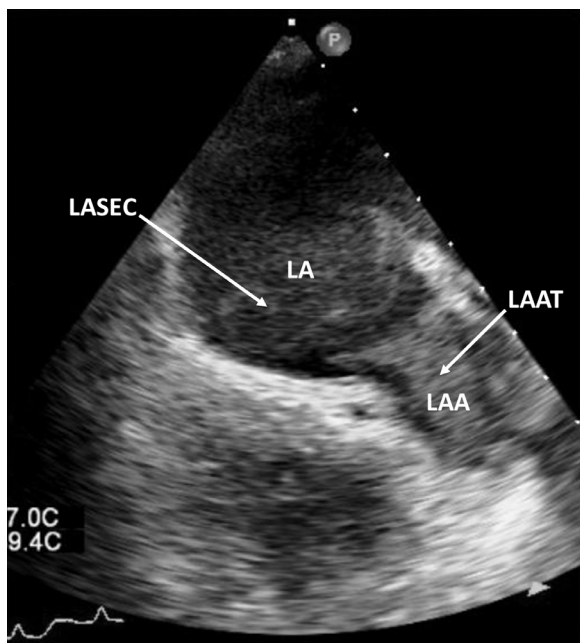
A transesophageal echocardiographic image of the left atrium and left atrial appendage showing left atrial spontaneous echo contrast grade 4 and a left atrial appendage thrombus in a patient with no-mild mitral regurgitation. LA=left atrium; LAA=left atrial appendage; LAAT=left atrial appendage thrombus; LASEC=left atrial spontaneous echo contrast.
